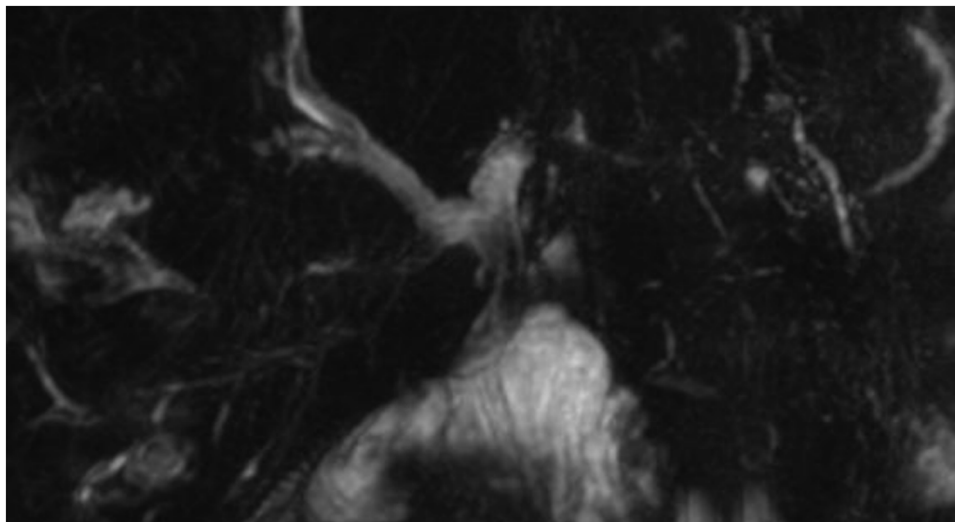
MRI performed 5 months after the operation.
